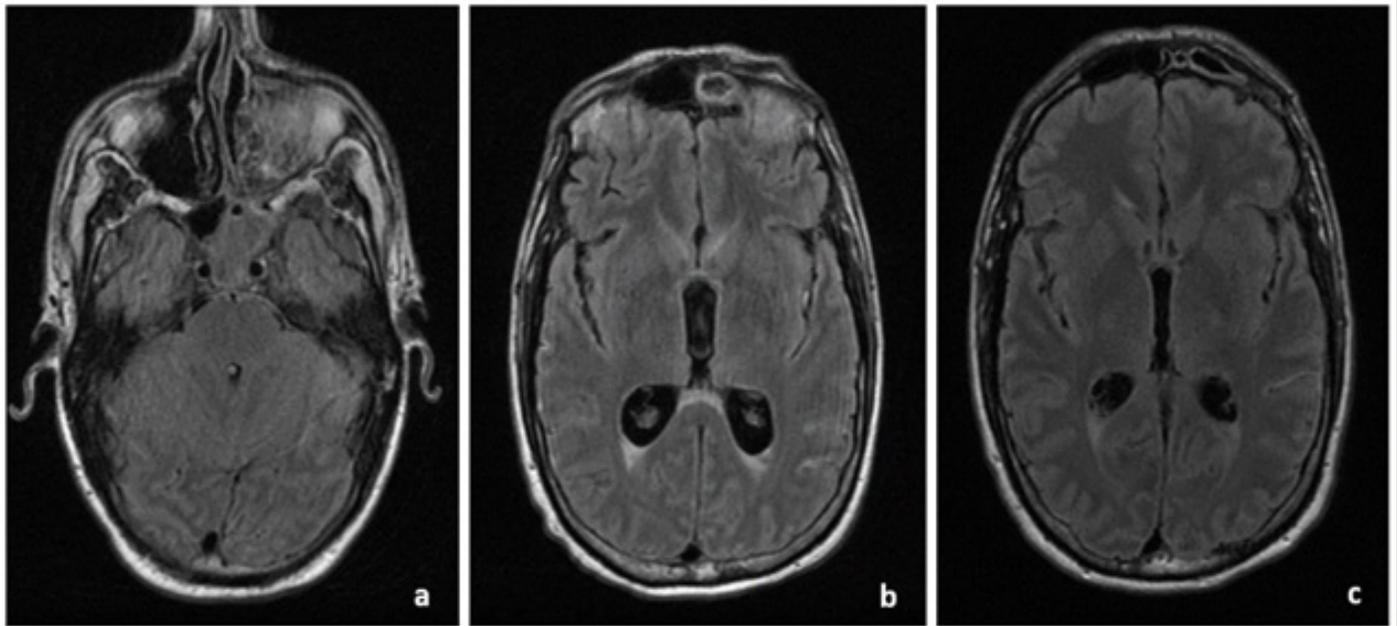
Increase in size of the third and lateral ventricles with normal size of the fourth ventricle (a,b; day 14 after admission) comparing with the MRI on day 2 after admission (c) suggesting obstructive hydrocephalus at the level of cerebral aqueduct.
